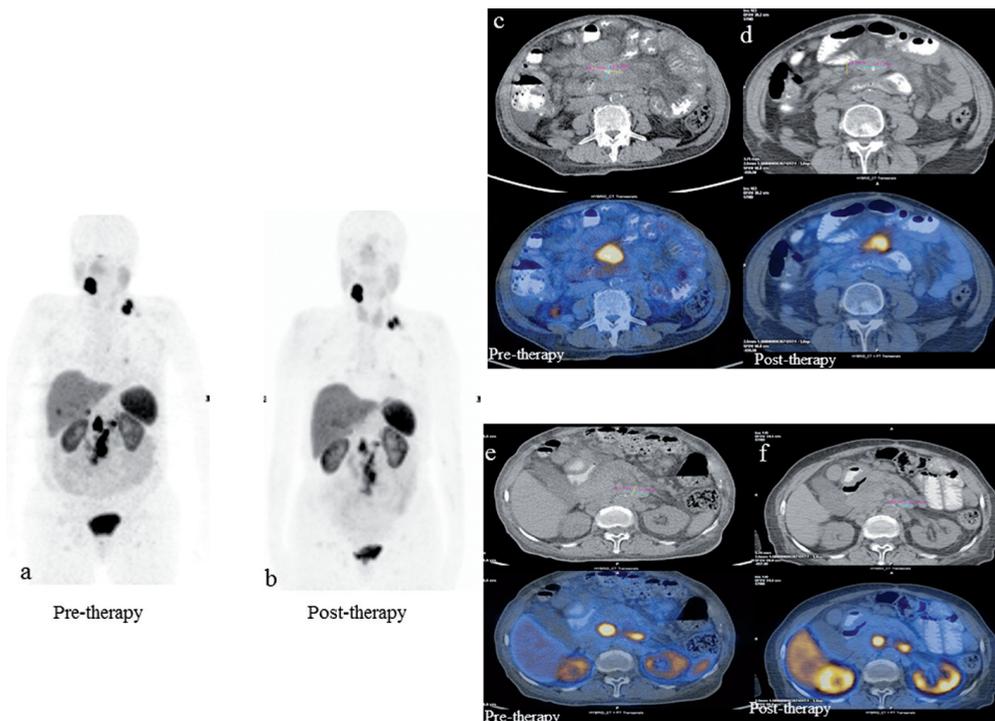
Ga-68 DOTATATE PET-CT was performed after 2 cycles (b,d,f) showed decrease in size and tracer uptake of lymph nodes in right neck, left supraclavicular fossa, abdominal lymph nodes and disappearance of foci in liver when compared to pre-therapy scan. (a,c,e). Mesenteric lymph node size decreased from 25x44 mm to 19x34 mm and paraaortic lymph node from 18x21 to 11x20 mm.
